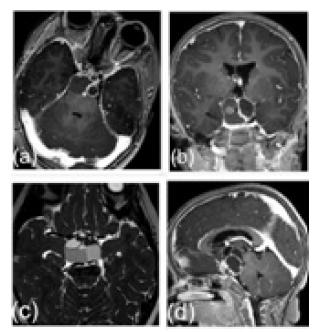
(a) (b) T1WI MRI brain with contrast shows Craniopharyngioma with multiple solid and cystic components
